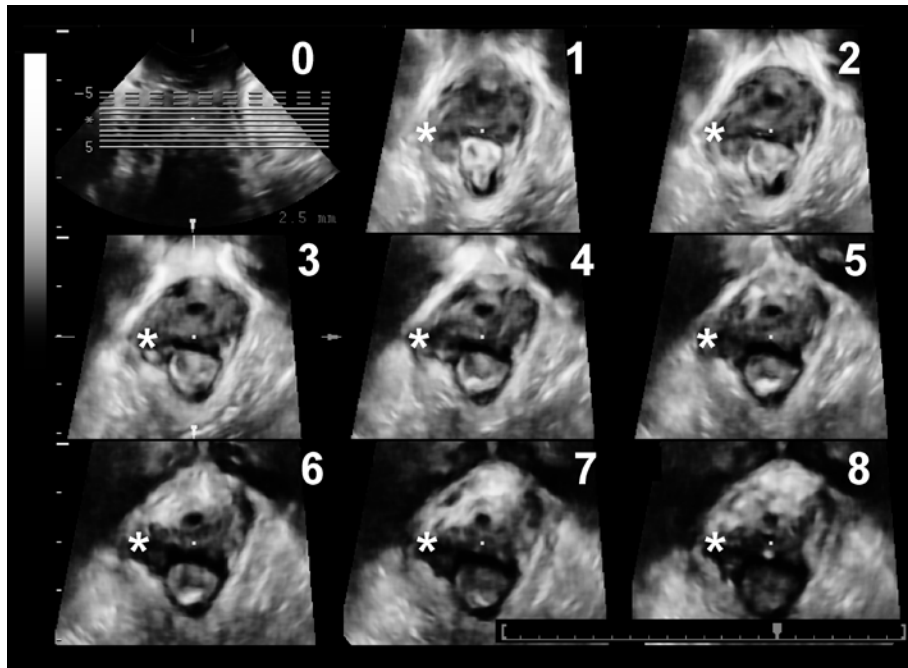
Tomographic ultrasound imaging of a right-sided (unilateral) complete levator avulsion. The asterisks identify the detachment of the puborectalis muscle from its insertion on the right inferior pubic ramus. From Dietz et al, Quantification of major morphological abnormalities of the levator ani. Ultrasound Obstet Gynecol 2007; 29: 329 – 34, with permission.
